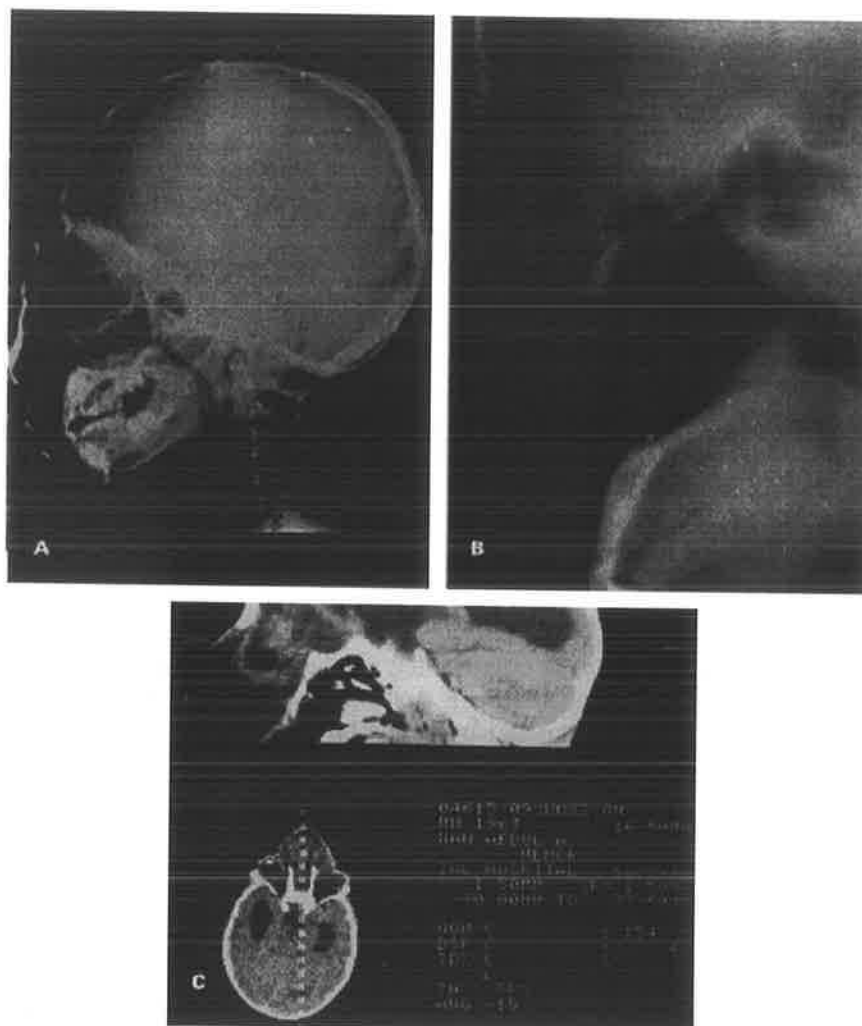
A Plain lateral radiograph showing a fronto-ethmoidal meningoencephalocele demonstrating the distortion at the root of the nose. B Sagittal tomogram giving a clearer definition of the relationship of the deformity to the face of skull and face. C Two-dimensional reconstruction from the computerised axial tomogram giving clearer definition of the deformity.
